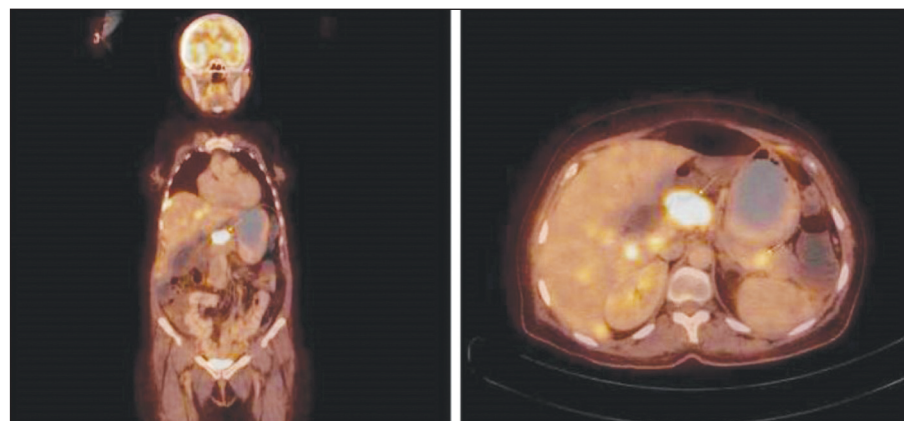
FDG-PET images of the primary tumor in the pancreas and its liver metastasis; coronal and transverse sections. FDG-PET: [¹⁸F] fludeoxyglucose-positron emission tomography.
